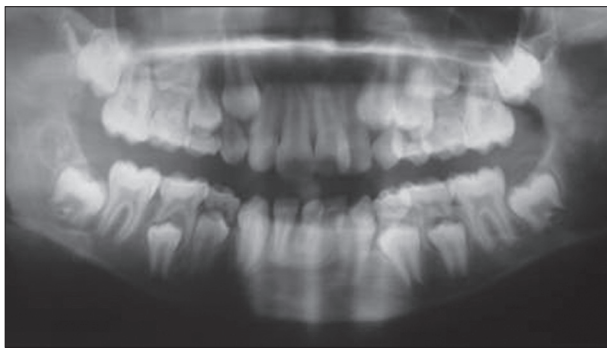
Orthopantomograph showing mesiodens in the midline of mandible with agenesis of both central incisors
